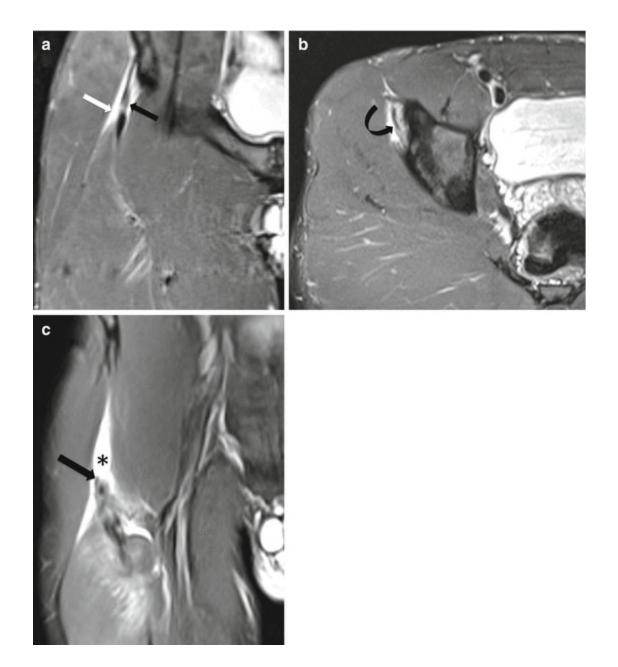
A 19-year-old male athlete presenting with groin pain after forceful soccer ball kicking. (a) Coronal and (b) axial fat-suppressed T2-weighted MRI show partial tear of both direct (black straight arrow) and indirect (black curved arrow) heads of rectus femoris. Moderate fluid collection is noted around the proximal tendon insertion indicating an acute lesion (white straight arrow). (c) Coronal fat-suppressed T2-weighted MRI 11 months later shows complete tear of the proximal attachment of the rectus femoris with a 4 cm retraction of the distal stump (arrow). An increase of fluid collection is also noted (asterisk)
